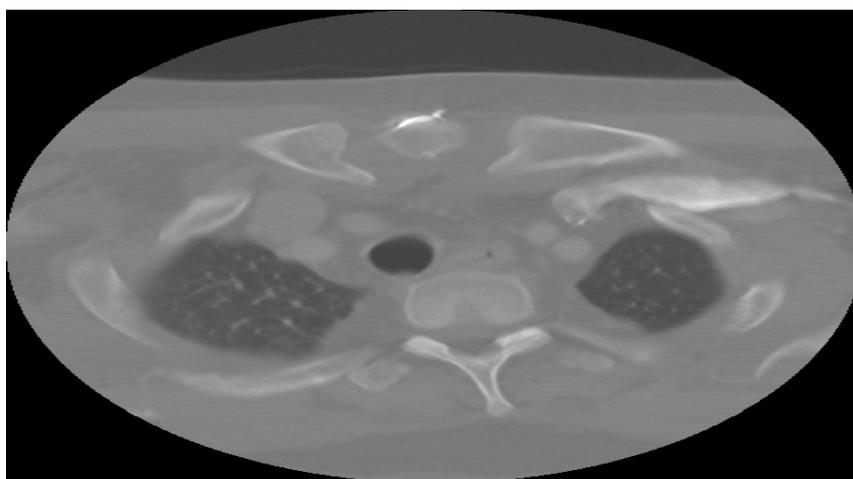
CT of neck soft tissue showing numerous micro abscesses.
